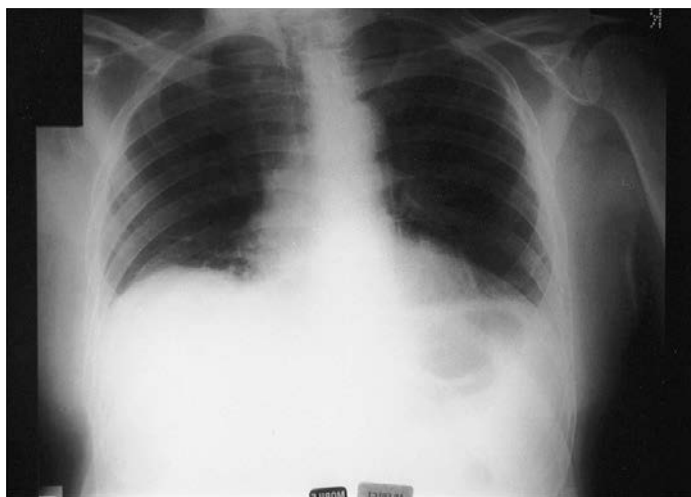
Chest radiograph of a patient with ALS and respiratory failure showing raised hemidiaphragms bilaterally.
